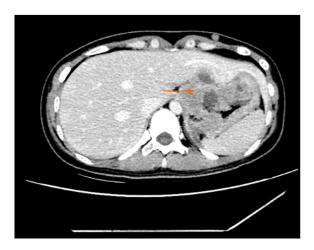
Computed tomography after the fourth chemotherapy cycle. Necrosis appeared in the middle of the tumor (arrow).
